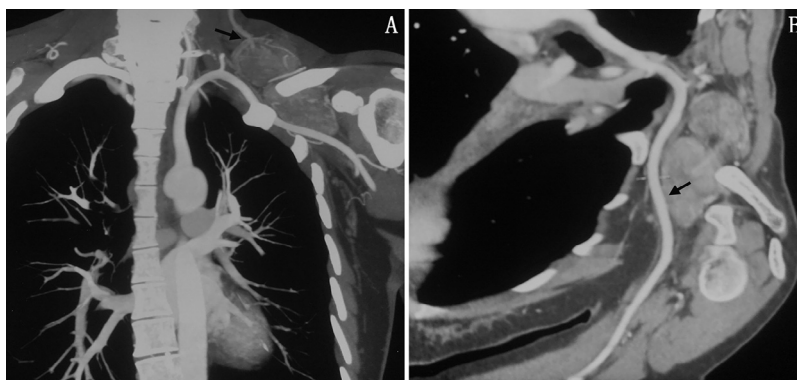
(A) CTA of supraclavicular fossa hibernoma. (B) Coronal CTA showing clear imaging of proximal blood vessels. CTA, computed tomography angiography.
